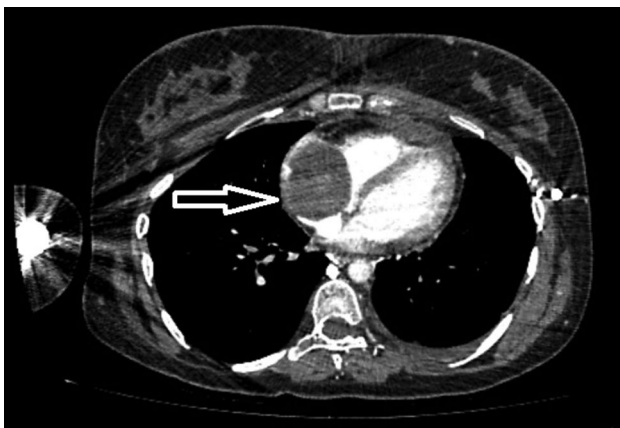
Preoperative computed tomography angiography image of the mass that fills the right atrium almost completely.
